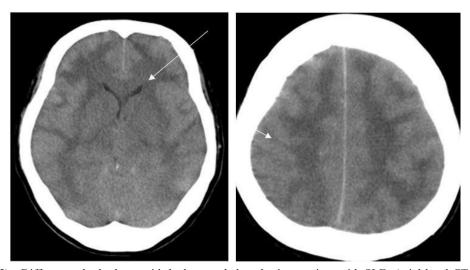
Diffuse cerebral edema with leukoencephalopathy in a patient with SLE. Axial head CT scans showing severe brain edema, reduction of cerebral ventricles, and disappearance of cerebral sulci.
